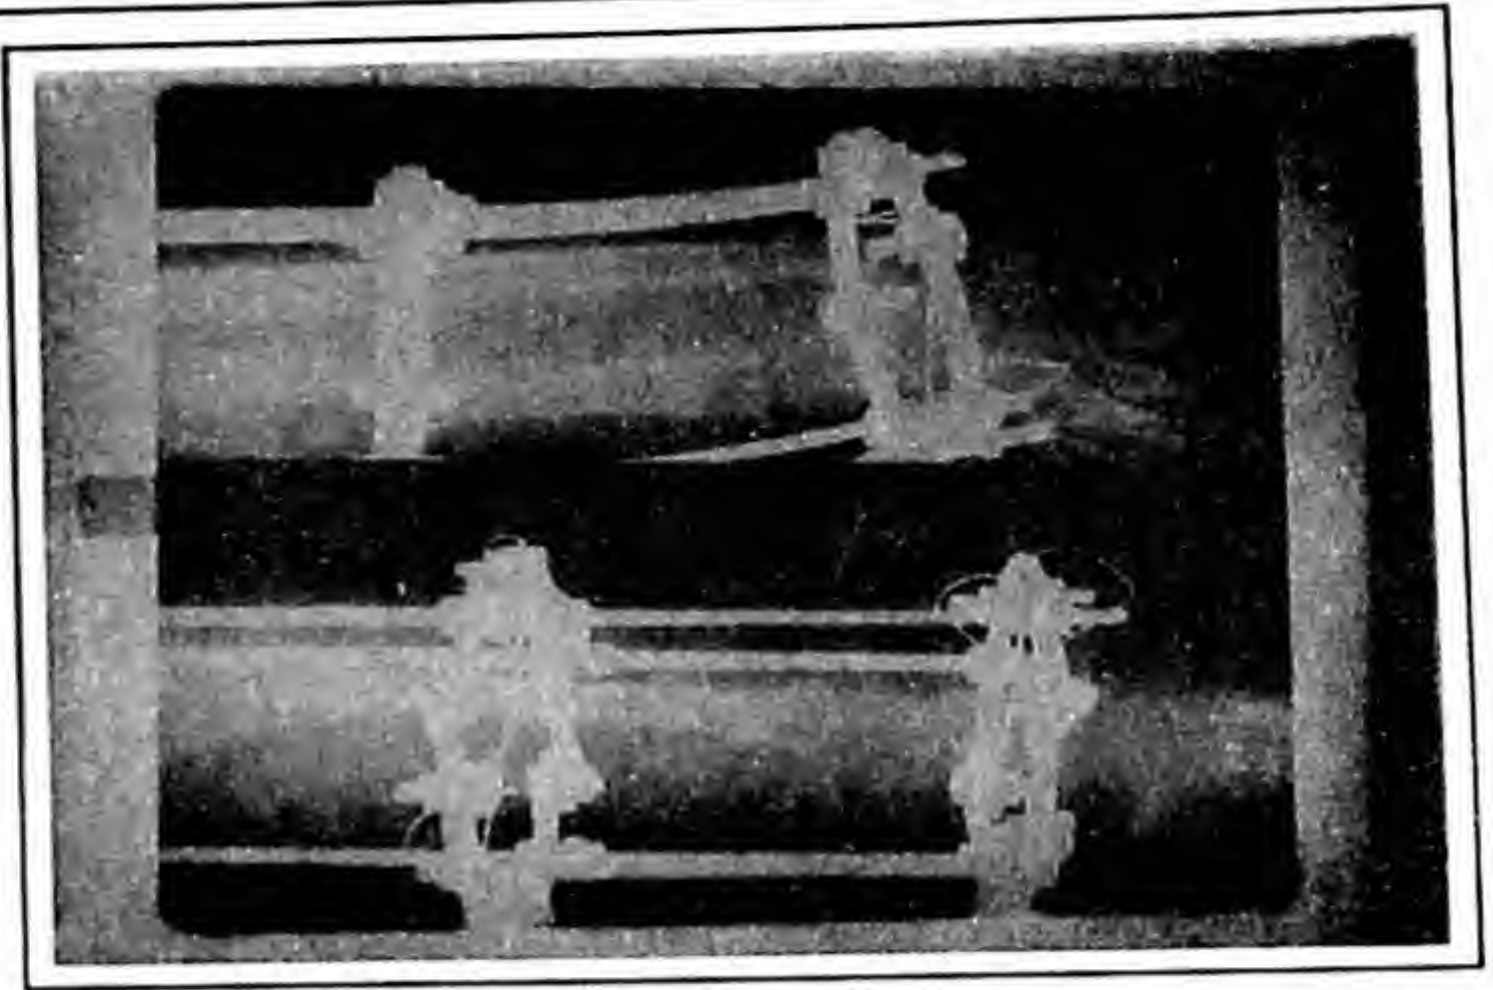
AP and Lateral Radiographs showing good regenerate
